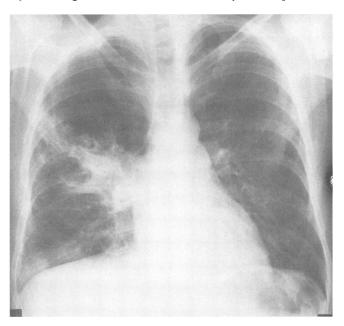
A chest radiograph (posteroanterior view) taken at the time of hospital admission shows a right upper lobe infiltrate.
